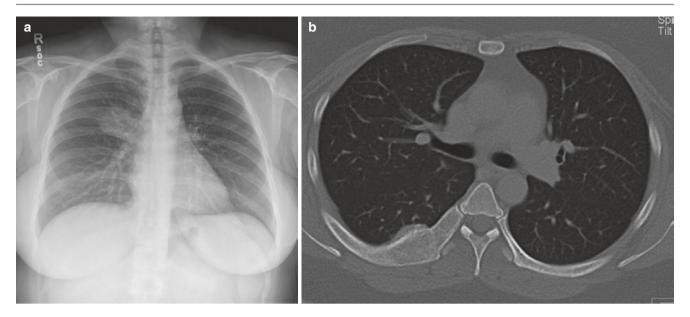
A 36-year-old woman with fibrous dysplasia. (a) Frontal chest radiograph shows an expansile sclerotic right sixth rib lesion mimicking a pulmonary or hilar mass. (b) Axial CT image reveals ground-glass density in the expansile rib lesion
